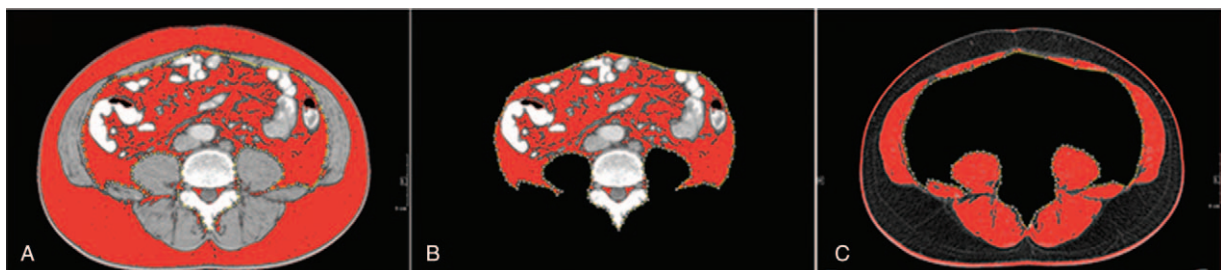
Measurement of body composition variables at the level of the third lumbar vertebra with CT images. (A) The areas of visceral fat and subcutaneous fat (red); (B) the areas of visceral fat (red); and (C) the areas of total skeletal muscle (red).
